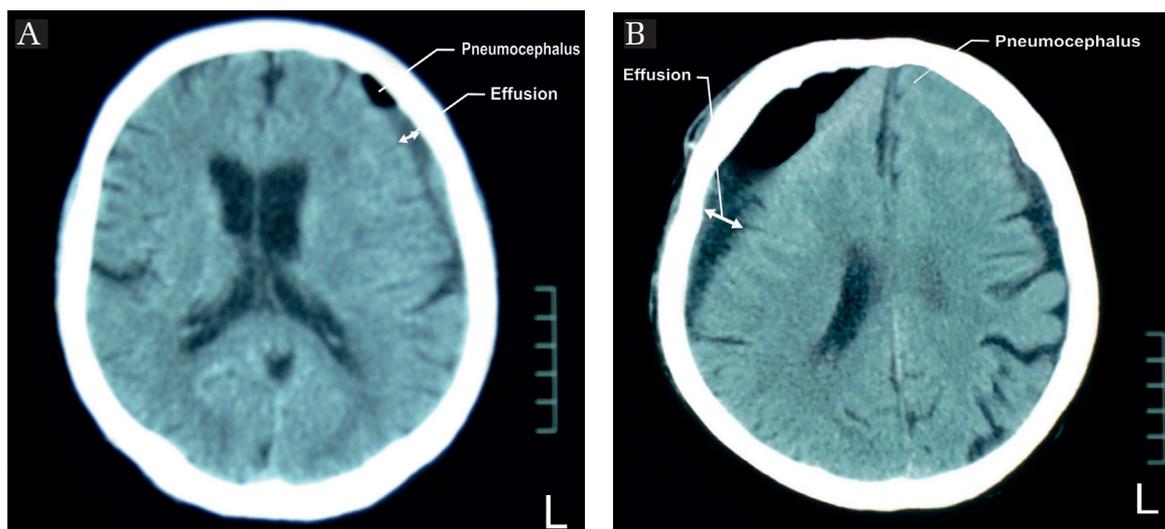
A: The CT scan obtained two days after surgery shows good re-expansion of the brain (with CTIM technique). B: The CT scan obtained two days after surgery shows insufficient re-expansion of the brain. There is prominent pneumocephalus (with BCOMI technique). CT: computed tomography, CTIM: catheterization and tearing of inner membrane, BCOMI: burr-hole craniotomy and outer membrane incision.
